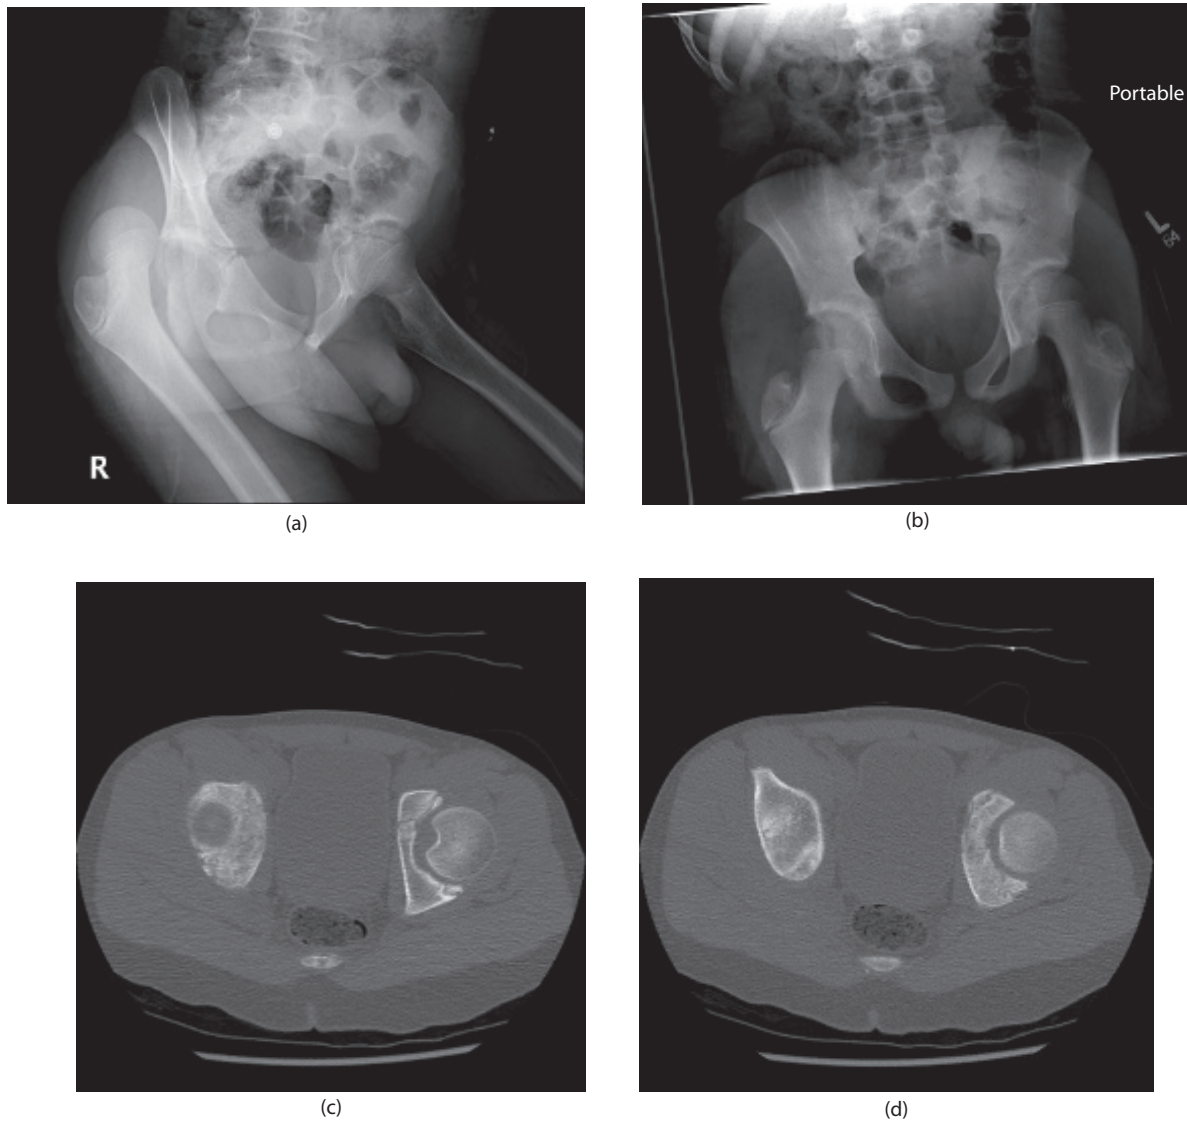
A 13-year-old male who sustained a right dislocated hip associated with a posterior wall acetabular fracture. Hip was reduced in the emergency department. On stress testing in the operating room, the hip was found to be stable, so no operative intervention was indicated for the fracture. (a) Initial pelvic x-ray showing right hip dislocation. (b) Pelvic x-ray after hip reduction. (c) and (d) Pelvic CT demonstrating small posterior wall acetabular fracture (<25%).
